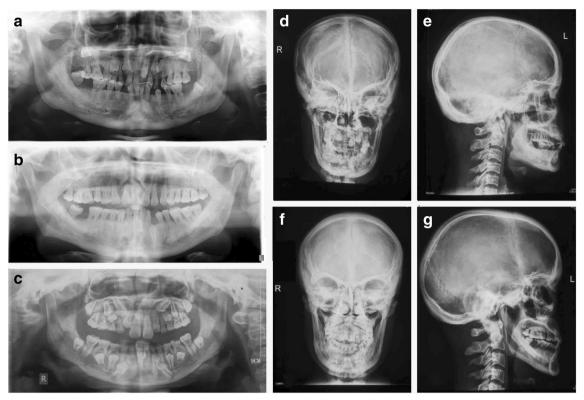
Radiological findings in CCD-affected relatives of the proband. a Panoramic radiograph of the proband's mother showing multiple unerupted teeth and one supernumerary tooth. b Panoramic radiograph of the proband's uncle showing one unerupted tooth. c Panoramic radiograph of the proband's cousin shows multiple retained deciduous teeth
